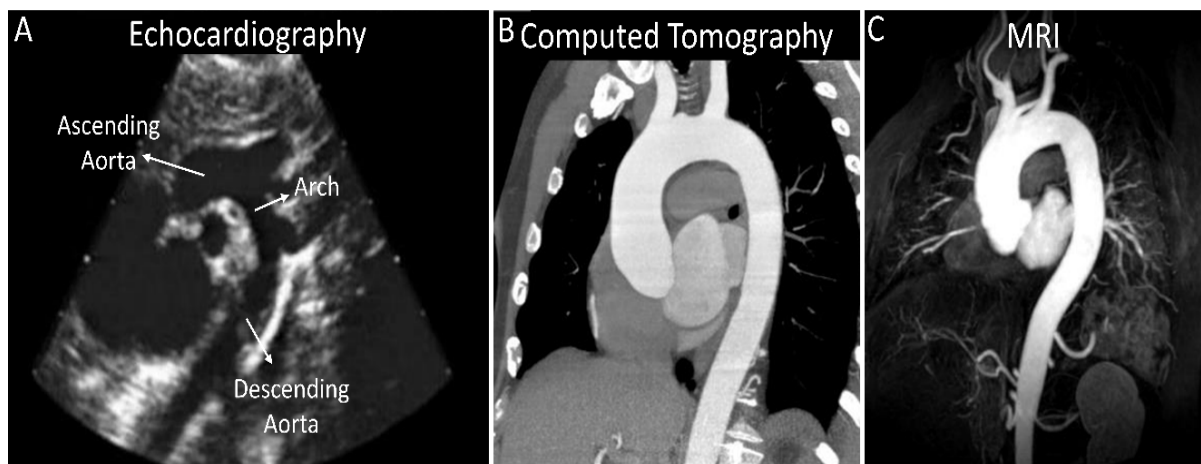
Clinical imaging techniques to diagnose aneurysm; echocardiography (A), CT (B), MRI (C).
